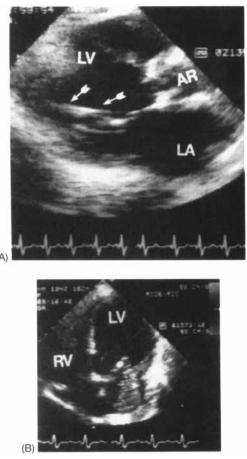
(A) Parasternal long-axis view (below) showing extensive papillary muscle calcification (arrows). Some calcification is also present in the aortic valve. (B) Mitral regurgitant jet in the same patient.
